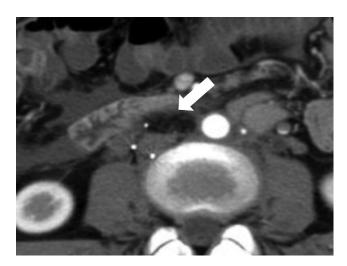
Postoperative axial arterial phase contrastenhanced computed tomography images demonstrate that the perforating struts of the IVC filter were successfully covered with an omental flap (white arrow).
